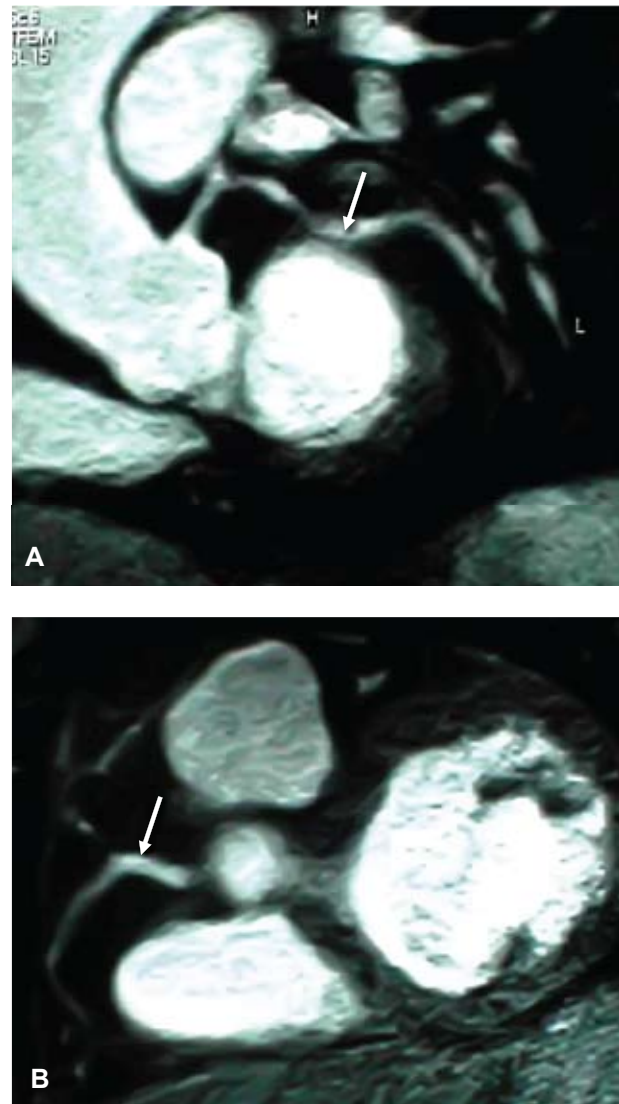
Magnetic resonance imaging of an ectatic left anterior descending coronary artery (A) and an ectatic right coronary artery (B).
